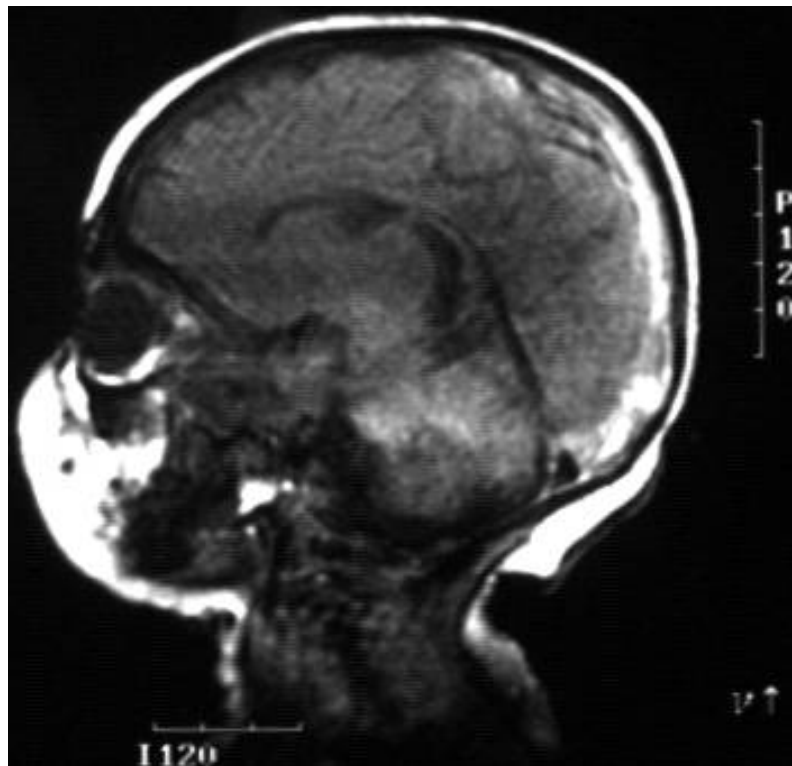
Sample magnetic resonance image of the child's head.
